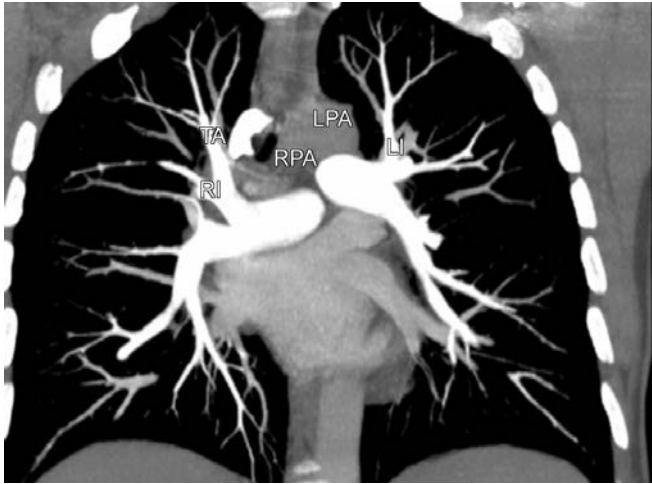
Coronal image of CT chest showing normal hilar pulmonary artery branching. The right main pulmonary artery (RPA) divides into an ascending trunk, truncus anterior (TA), primarily supplying the right upper lobe, and a descending trunk, interlobar branch (RI), supplying mainly the right middle and lower lobes. The left pulmonary artery (LPA) continues as the descending or interlobar left pulmonary artery (LI), giving rise to segmental branches of the left upper and lower lobes
